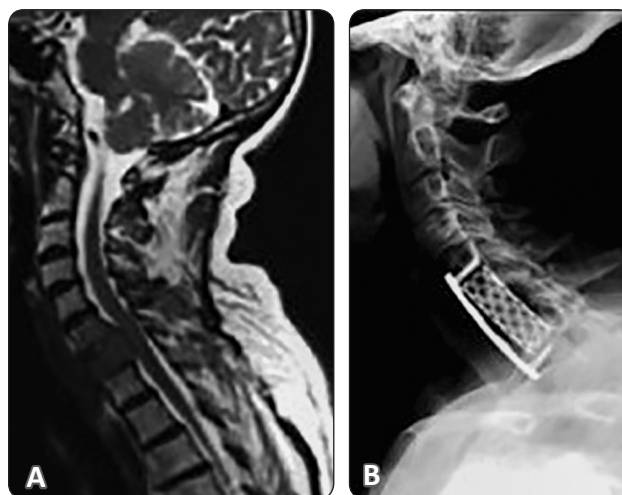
(A) MRI cervicodorsal spine T2 weighted image in a patient with metastatic breast disease and lysis of C7. (B) plain X-ray after reconstruction with titanium mesh and anterior plate fixation of the cervicodorsal spine.
